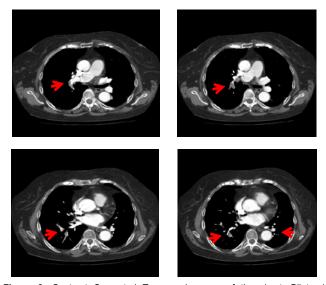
Contrast Computed Tomography scan of the chest. Bilateral presence of multiple emboli in the branches of the pulmonary arteries (red arrows).
